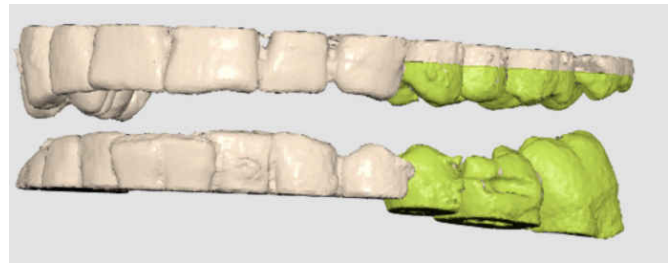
Matching the two data sets is only possible once the complete maxilla and mandible are imported based on the intraoral scan data. In the green CBCT data, a difference can be seen on the buccal exterior compared to the scan data. This is marked with the yellow arrow.
